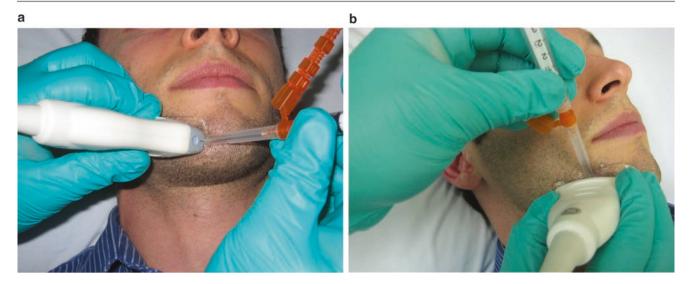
Ultrasound-guided mental nerve injection technique (a) Example of in-plane needle position, (b) example of out-of-plane needle position
